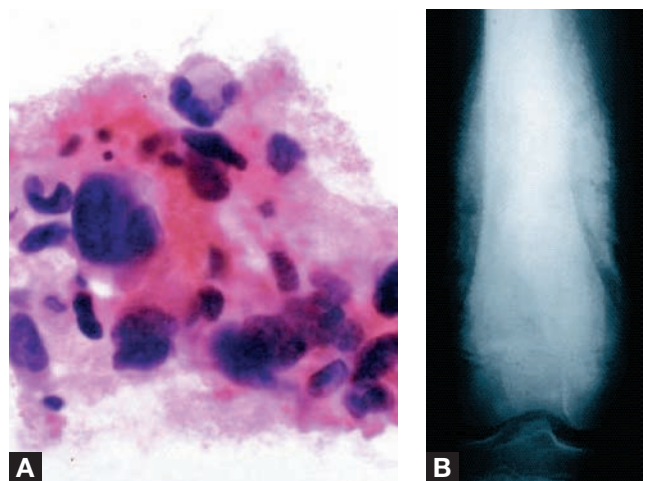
(A) The fine-needle aspirate (FNA) reveals a cluster of cells with marked nuclear atypia. The nuclei are enlarged, irregular, and hyperchromatic. This demonstrates a pleomorphic malignant neoplasm. (B) The FNA, in combination with the initial radiographic appearance, is diagnostic of osteosarcoma.
